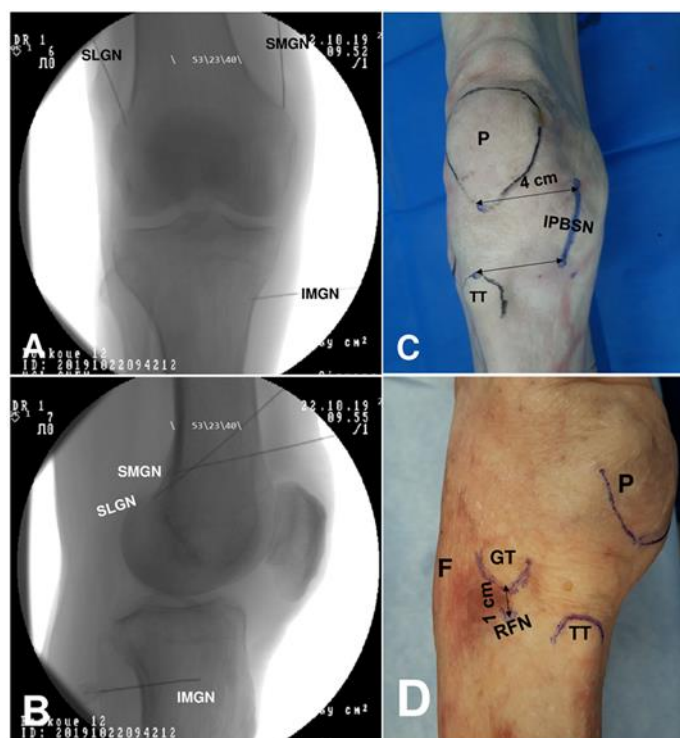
Revised anatomical targets for fluoroscopic guided RF ablation of genicular nerves. (A) A-P X-ray view. (B) Lateral X-ray view. (C) Landmarks for IPBSN targeting. (D) Landmarks for RFN targeting. SLGN, superior lateral genicular nerve; SMGN, superior medial genicular nerve; IMGN, inferior medial genicular nerve; IPBSN, infrapatellar branch of saphenous nerve; RFN, recurrent fibular nerve; P, patella; TT, tibial tuberosity; GT Gerdy's tubercle; F, fibula head.
